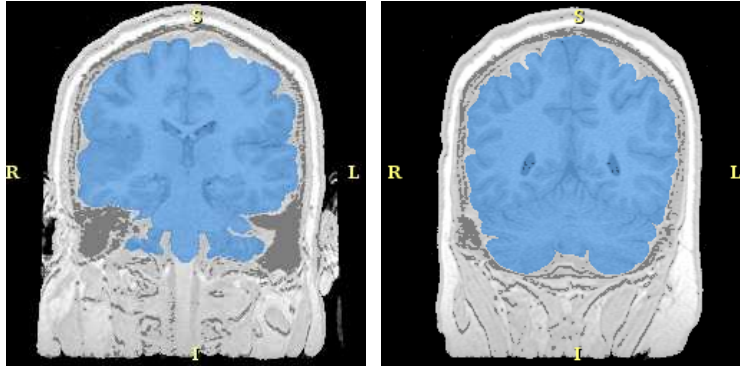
Patient Example 2 - Brain Mask. Legend: Non-brain(White), Brain(Blue). The figure shows the resulting brain mask from initial segmentation overlaid on the corresponding T1-weighted MRI volume. Further processing to separate the cortical volume into gray-matter, white-matter and cerebral-spinal-fluid is not carried out in this example.
